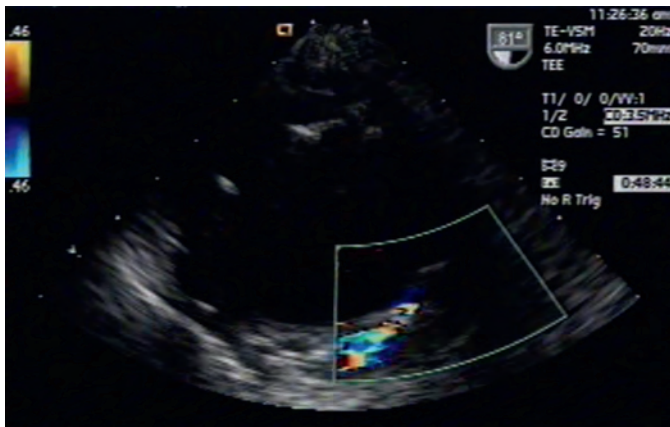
Endoleak. Upper esophageal short-axis aortic arch. An endoleak is demonstrated between two portions of an aortic endograft that was not visualized by angiography. Color-flow Doppler demonstrates flow from the endograft lumen into the aneurysm.
